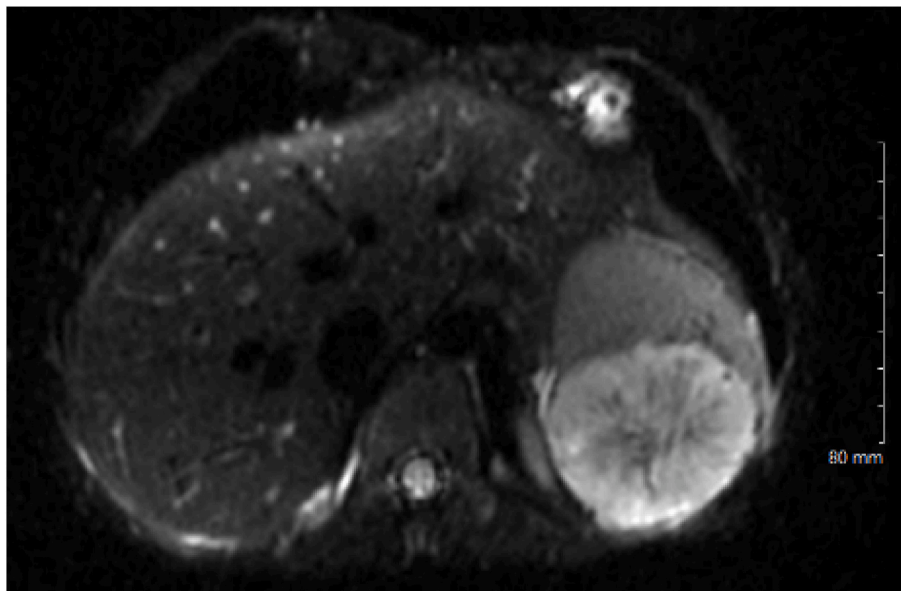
Hamartoma on MRI.
